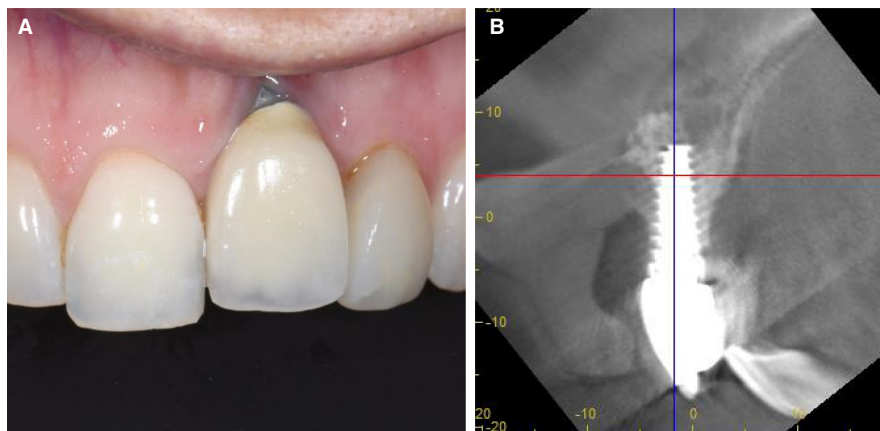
A, The implant in the maxillary left central incisor site has been placed in a facial malposition. This has resulted in recession of the facial mucosa. The implant was placed about 10 years previously, and vertical growth changes have accentuated the incisal edge and mucosal margin discrepancy. B, The corresponding CBCT scan confirms the facial malposition of the implant. The sagittal view has been rotated so that the blue vertical line coincides with the central long axis of the implant. With this orientation, it can be observed that the incisal edge of the prosthesis is palatal to the axis of the implant. CBCT, cone beam computed tomography
